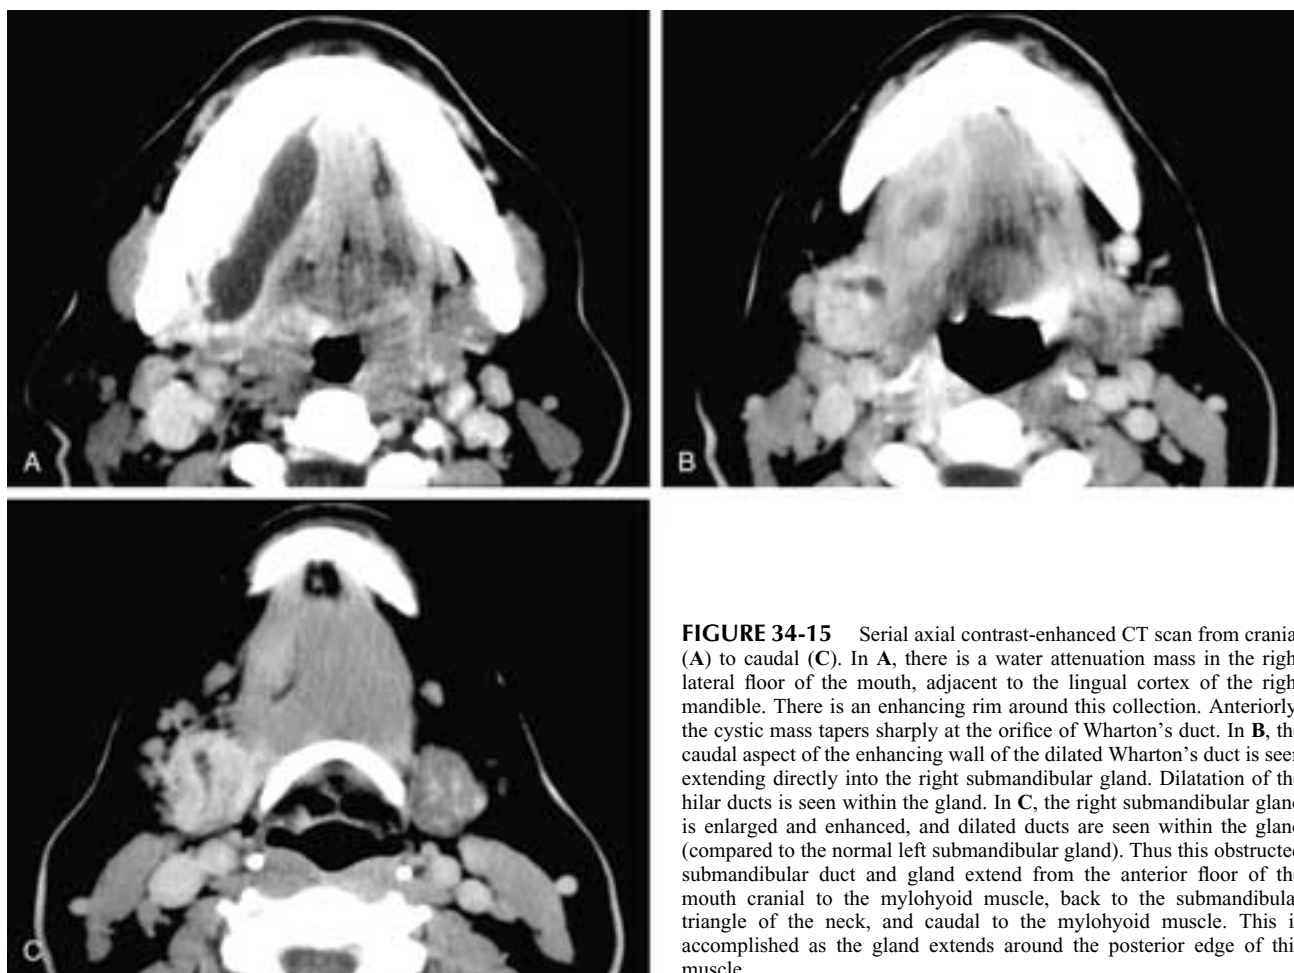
Serial axial contrast-enhanced CT scan from cranial (A) to caudal (C). In A, there is a water attenuation mass in the right lateral floor of the mouth, adjacent to the lingual cortex of the right mandible. There is an enhancing rim around this collection. Anteriorly, the cystic mass tapers sharply at the orifice of Wharton's duct. In B, the caudal aspect of the enhancing wall of the dilated Wharton's duct is seen extending directly into the right submandibular gland. Dilatation of the hilar ducts is seen within the gland. In C, the right submandibular gland is enlarged and enhanced, and dilated ducts are seen within the gland (compared to the normal left submandibular gland). Thus this obstructed submandibular duct and gland extend from the anterior floor of the mouth cranial to the mylohyoid muscle, back to the submandibular triangle of the neck, and caudal to the mylohyoid muscle. This is accomplished as the gland extends around the posterior edge of this muscle.
